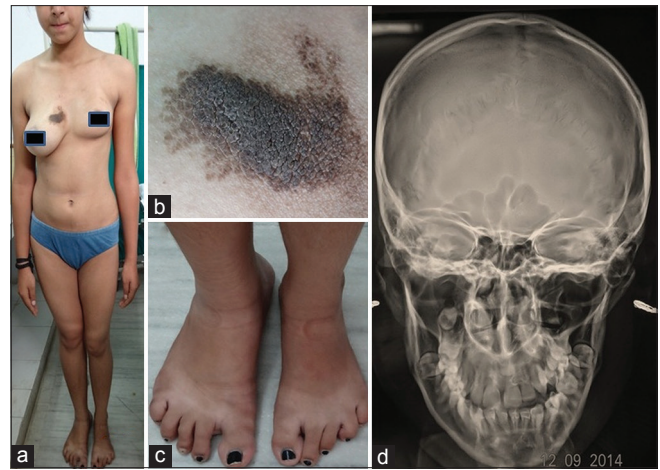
(a) Asymmetry of the trunk and face (hemihypertrophy), (b) verrucous epidermal nevus over breast, (c) right foot hypertrophy, (d) skull X-ray shows bony facial asymmetry
